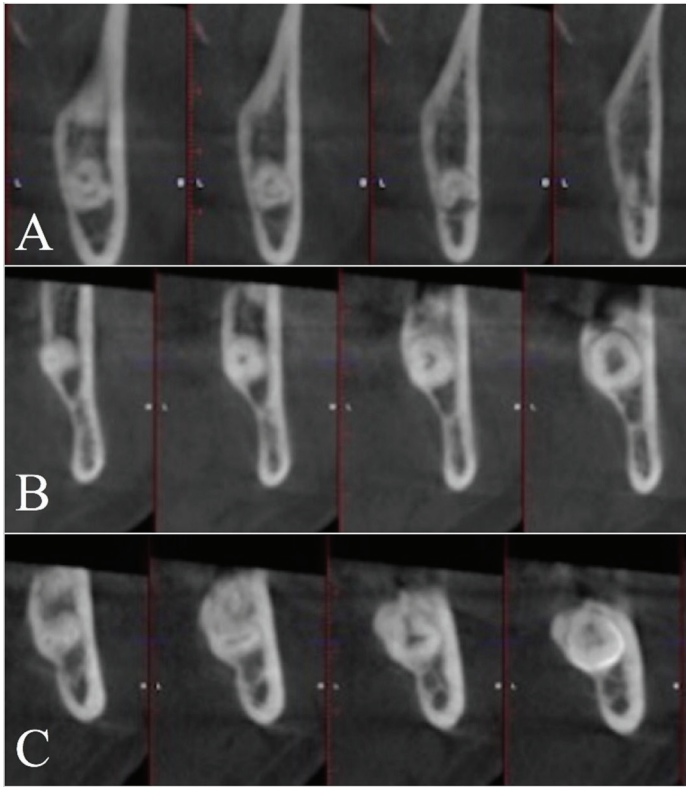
Bone morphology at the 3M site in a coronal CBCT image. A, round shape (flat shape on buccal and lingual sides), B, lingual concavity (round on buccal side and concave on lingual side), and c, lingual extended (bone expansion to lingual site with distinct concavity, with round shape on buccal site)
